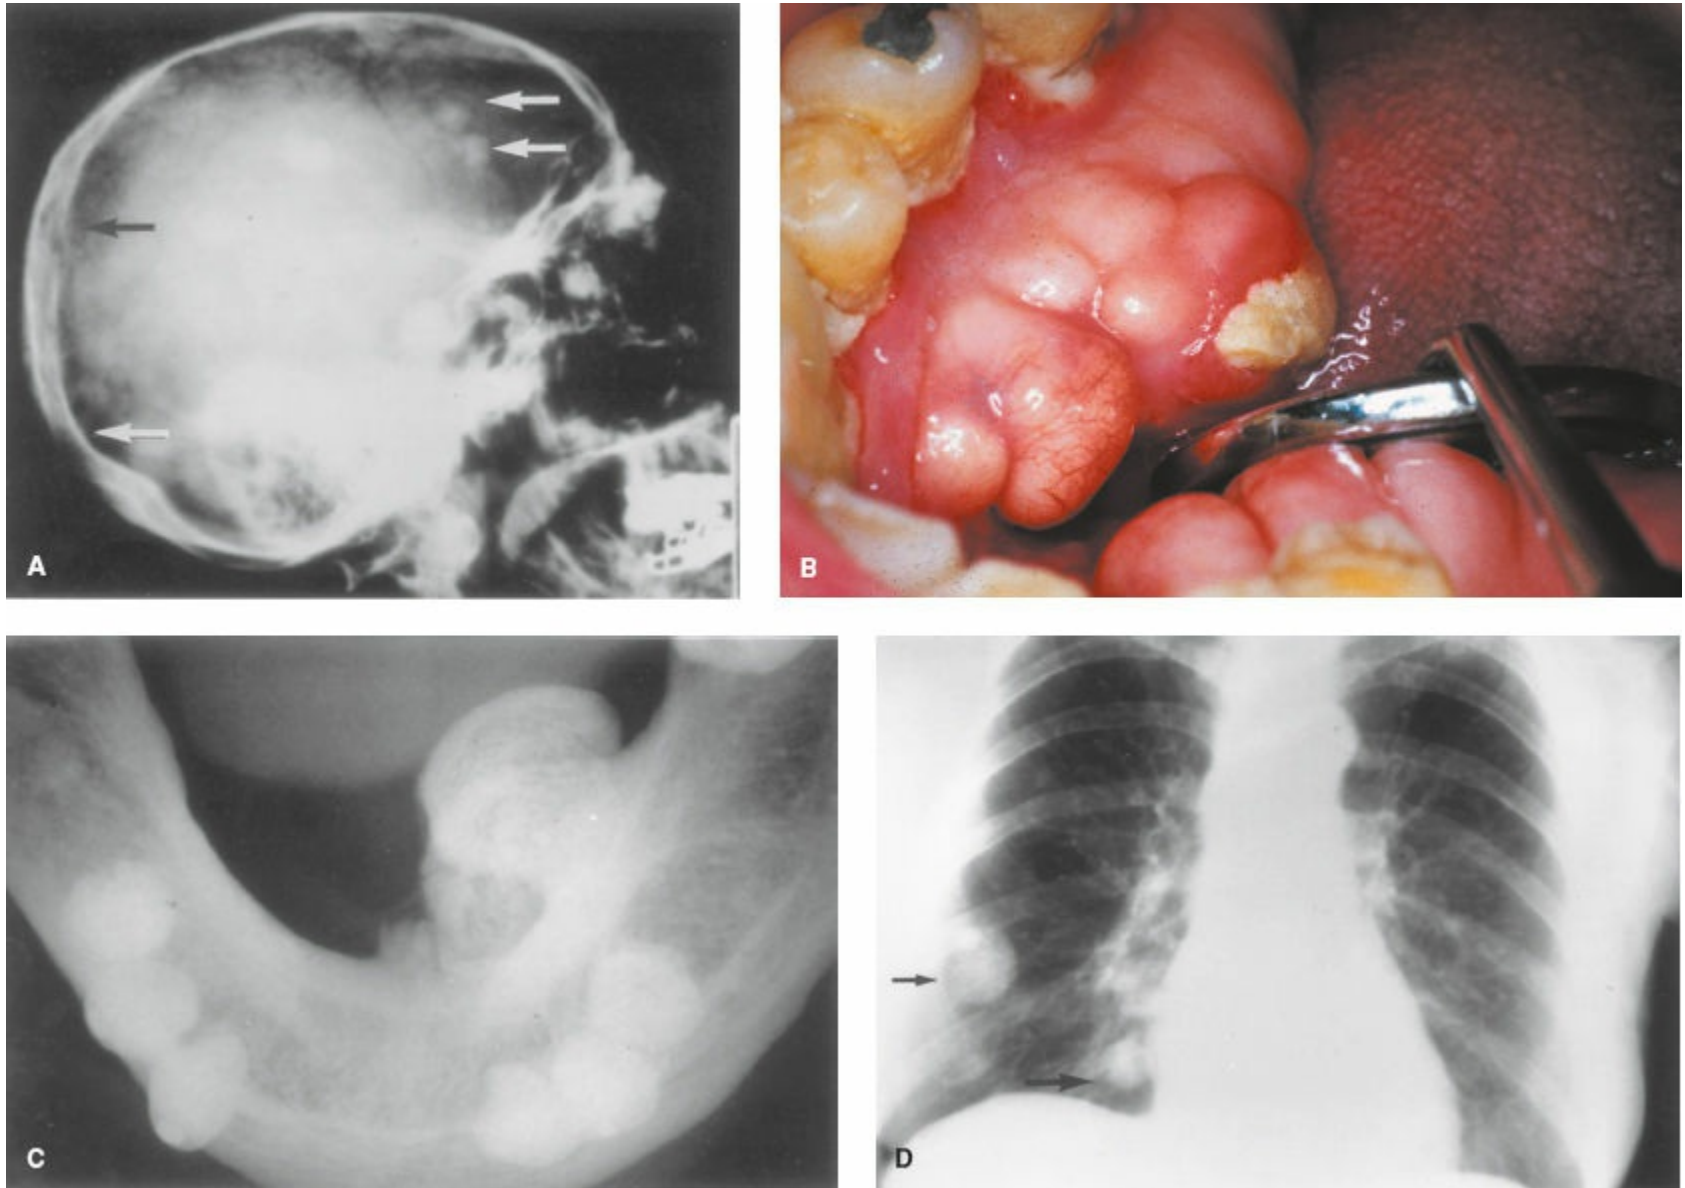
Extraintestinal manifestations of familial adenomatous polyposis (FAP). A: Skull film demonstrating osteomas of the calvarium (*arrows*). B: Photograph of the mandible demonstrating protuberant mandibular osteomas. C: Mandibular radiograph demonstrating a large osteoma of the mandible. D: Chest radiograph demonstrating multiple fibromas (*arrows*) in a patient with FAP.
